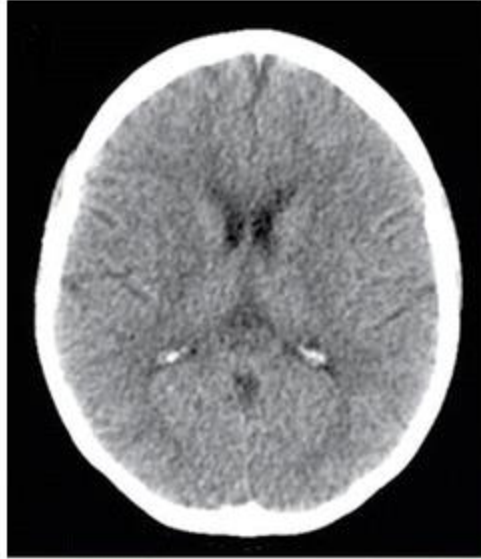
Example of typical CT scan tomographic image of the human brain inside the skull. [Ginat and Gupta, 2014].
